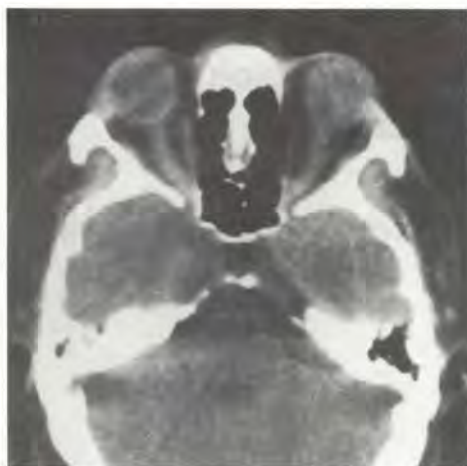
Axial CT-Scan showing narrow-diffuse enlargement of the optic nerves in patient 1.
